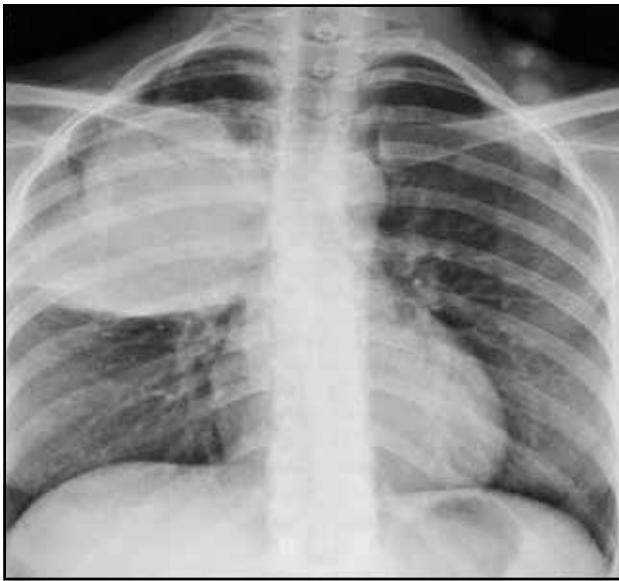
Chest X-ray 24 hours after the pulmonary biopsy: opacification located in the right superior pulmonary lobe, with no other local complications.
